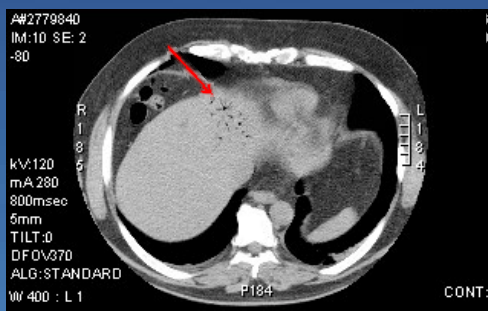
CT demonstrating HPVG
